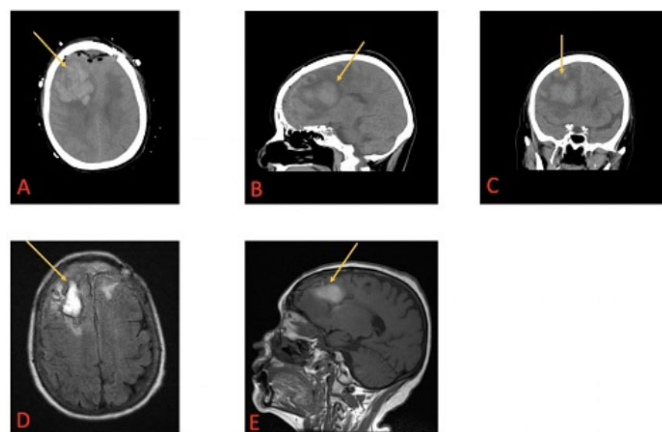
(A) Date of admission transverse CT image of brain abscess with mass effect and vasogenic edema; arrow denotes abscess. (B) Date of admission sagittal CT image of brain abscess with mass effect and vasogenic edema; arrow denotes abscess. (C) Date of admission coronal CT images of brain abscess with mass effect and vasogenic edema; arrow denotes abscess. (D) 2.5 months postoperative craniotomy and resection, MRI transverse image; arrow denotes abscess. (E) 2.5 months postoperative craniotomy and resection, MRI sagittal image; arrow denotes abscess.
